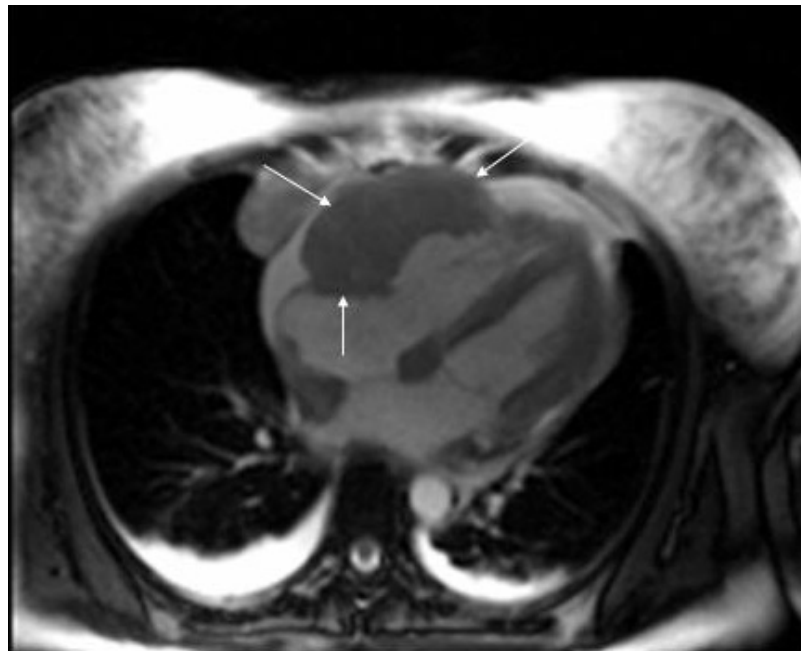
Cardiac magnetic resonance image. Arrows mark the mass lesion.
